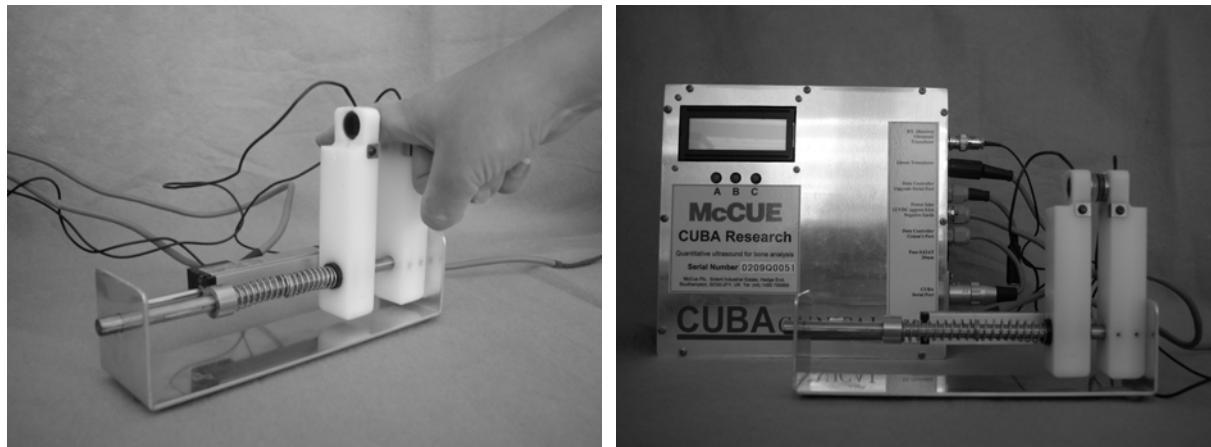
The BOSCOS Ultrasound Device
